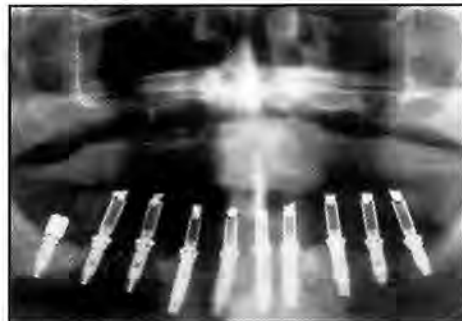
Panoramic radiograph following the delivery of the new fixed provisional prosthesis. All TIs have been removed.
